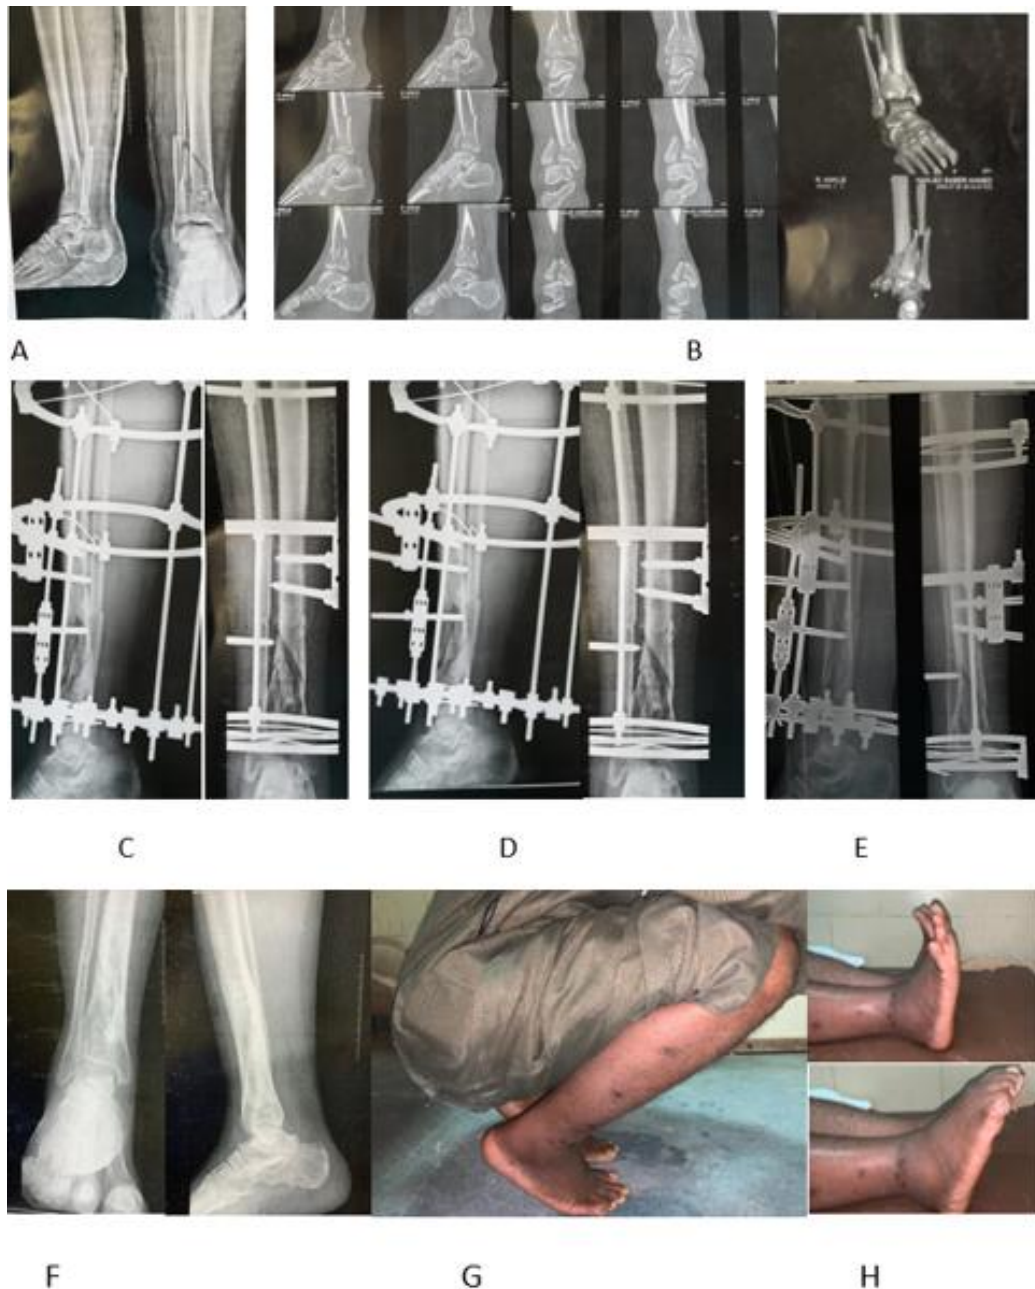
Male patient, 30 years old, motor car accident, (A) X-ray showed pilon Fracture with ipsilateral Fracture ankle type C. (B) CT scan showed the articular surface and metaphyseal comminution. (C) The patient was operated on with definitive IF. (D) three months follow-up. (E) At 6 Months Follow-up, X-ray shows Ilizarov removal after the complete bone union. (F) Follow-up after 12 months, normal ankle ROM.
